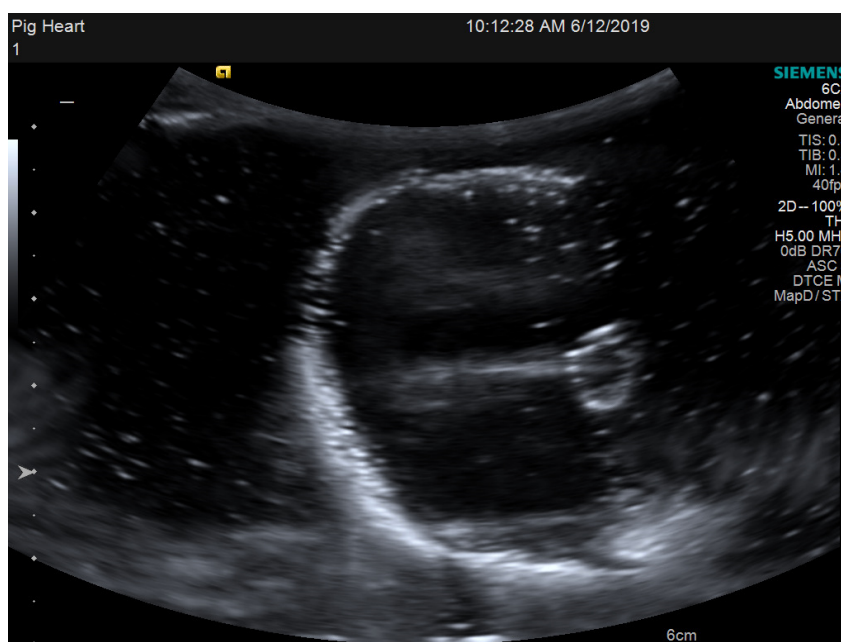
Ultrasound imaging of the ballistic mould from figure U3.
